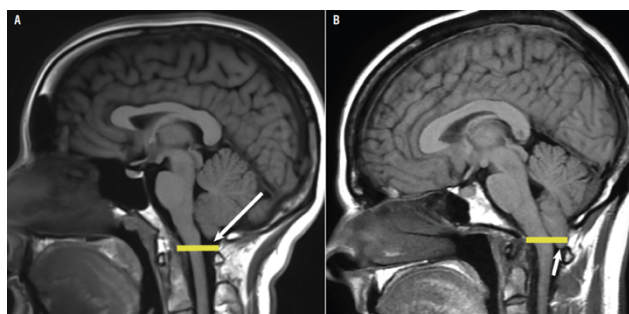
MRI showing Chiari malformation. A normal MRI in the left; and MRI demonstrating a tonsillar ectopia >5mm below the foramen magnum, representing a patient with CIM in the right. Extracted from (23).
